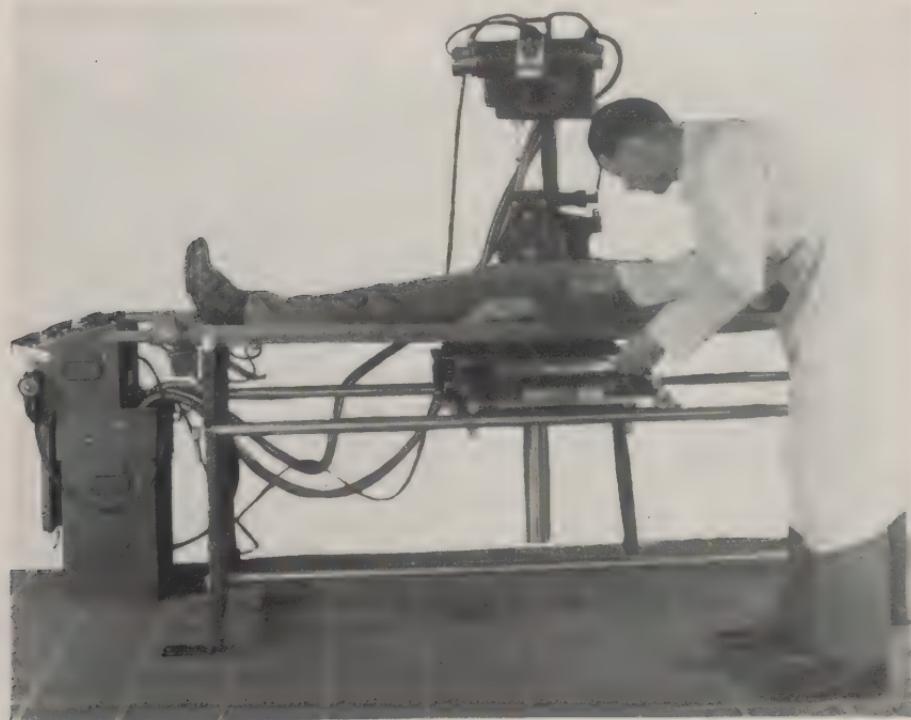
Item No. 96085 assembled with item No. 96145 and item No. 96070—the adaptation for routine roentgenography.
